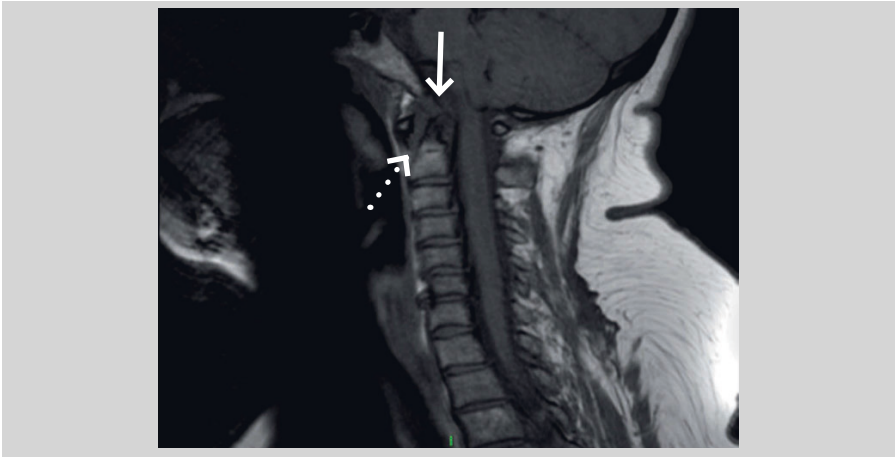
Atlantoaxial subluxation. Sagittal T1 magnetic resonance imaging (MRI) demonstrates widening of the distance between the anterior arch of C-1 and the dens (dotted arrow). There is erosion of the dens with a pointed configuration (arrow).
